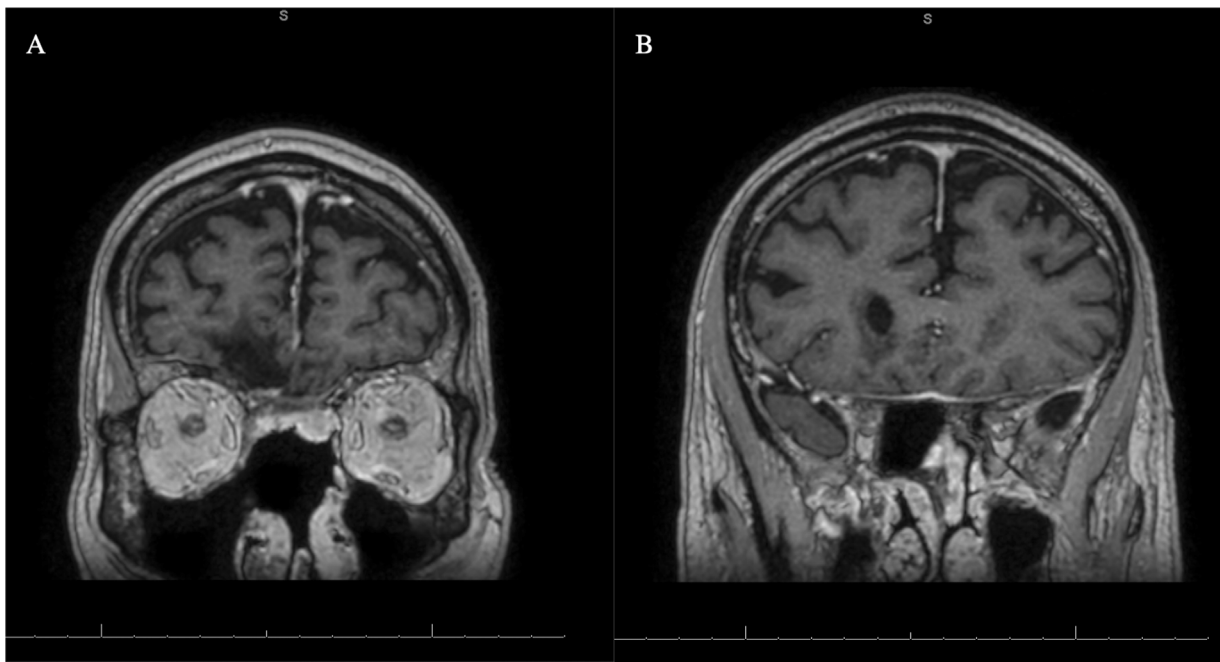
Postoperative magnetic resonance imaging (MRI) (A, B) images showing absence of residual tumor.
